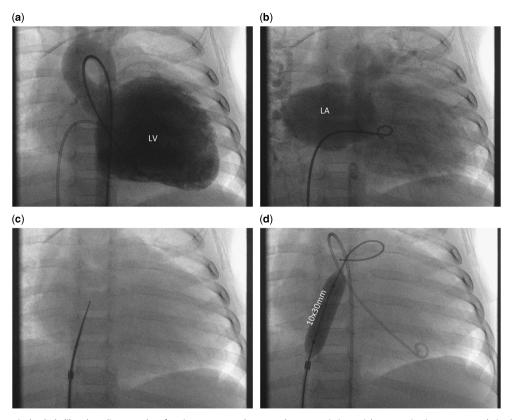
(*a*–*d*) Left ventricular (LV) dilated cardiomyopathy of patient no. 17 at day 445, when a restrictive atrial communication was created. On (*a*) the left ventricular angiography with an extreme dilated LV is depicted (MRI; z-score of left ventricular end-diastolic dimension was 6.5). (*b*) Angiographically obtained left atrial dimension before the atrial septum puncture. (*c*) Trans-septal needle advanced through a 6F Cook sheath in anterior–posterior plane; before the atrial septum is punctured the correct posterior direction to the left atrium has additionally to be demonstrated in the 90° lateral frame (see text); (*d*) Final Powerflex® balloon fully inflated to a diameter of 10 mm within the atrial septum. A diagnostic Pigtail catheter is still re-advanced in the LV cavity.
